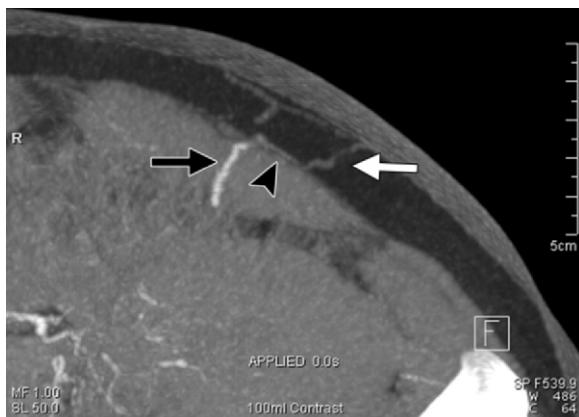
Axial MIP image from CT angiography depicts the intramuscular (black arrow), subfascial (arrowhead), and subcutaneous (white arrow) segments of a deep inferior epigastric perforating artery.
